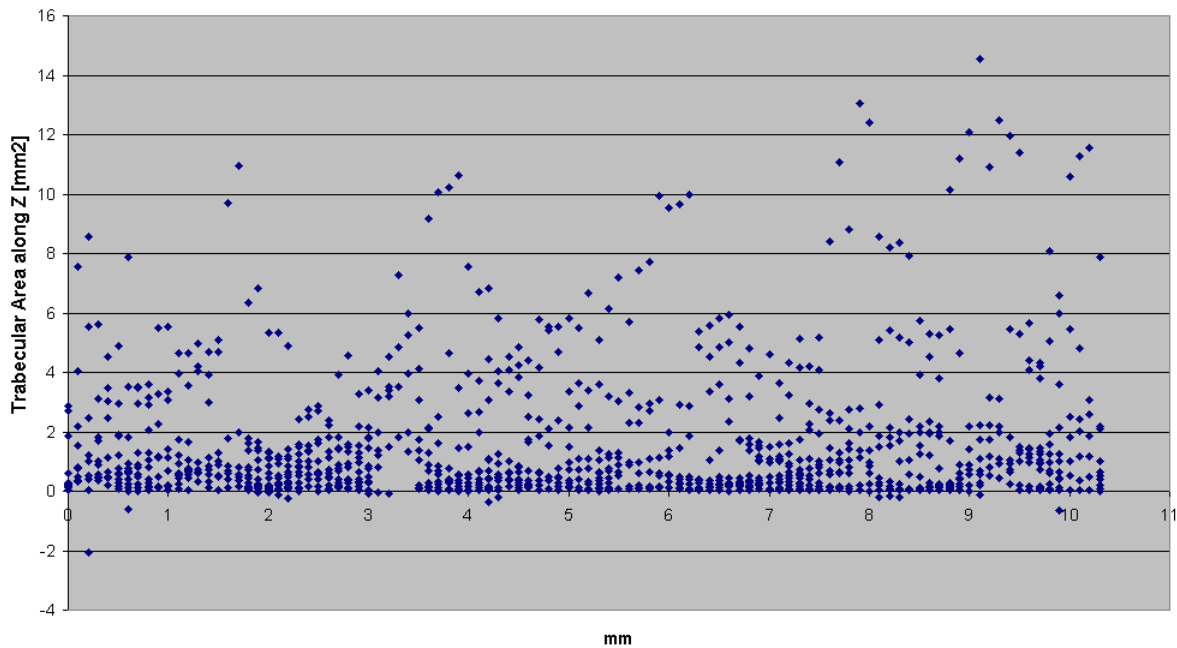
Cubic  $\mu$ CT sample: trabecular area distribution along Z
